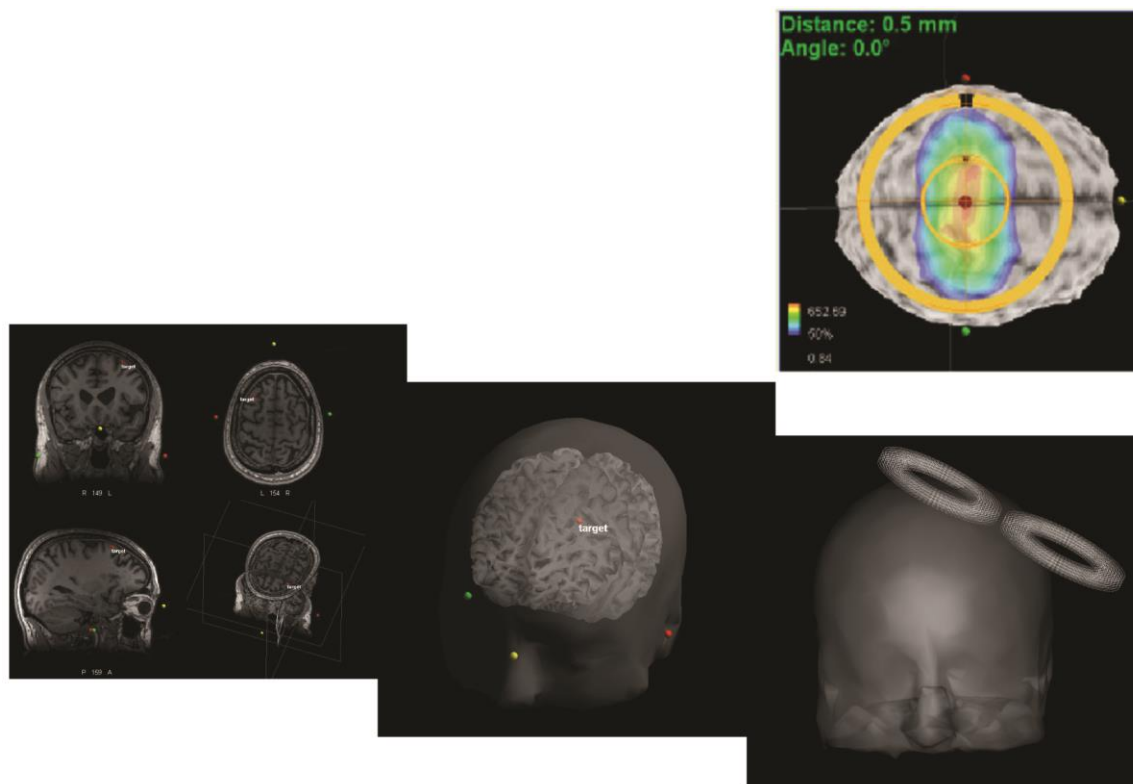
Neuronavigation for rTMS therapy. Subject-specific MRI was used for 3D reconstruction of the head volume. High-frequency rTMS (10Hz) at 110% of the RMT was then applied at the L-DLPFC with real-time targeting using the ANT neuro-navigation system.
